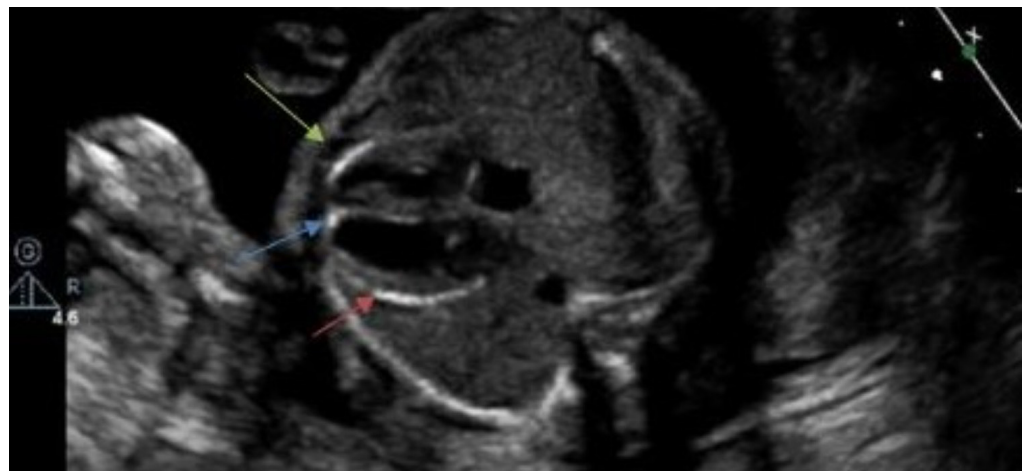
Fetal apical 4 chamber view showing small apical pericardial effusion (green arrow), echo-bright left ventricular free wall (red arrow), echo-bright right ventricular free wall, and apical ventricular septum (blue arrow) suggestive of diffuse endocardial fibroelastosis. The echogenicity is also seen involving the left ventricular epicardial layer (red arrow).
